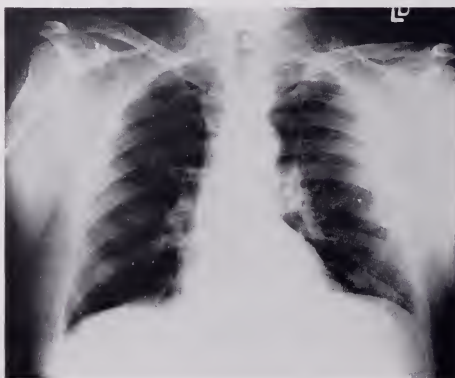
Roentgenogram of the chest after the appearance of the pancreatic pseudocyst indicating elevation of the left leaf of the diaphragm.
